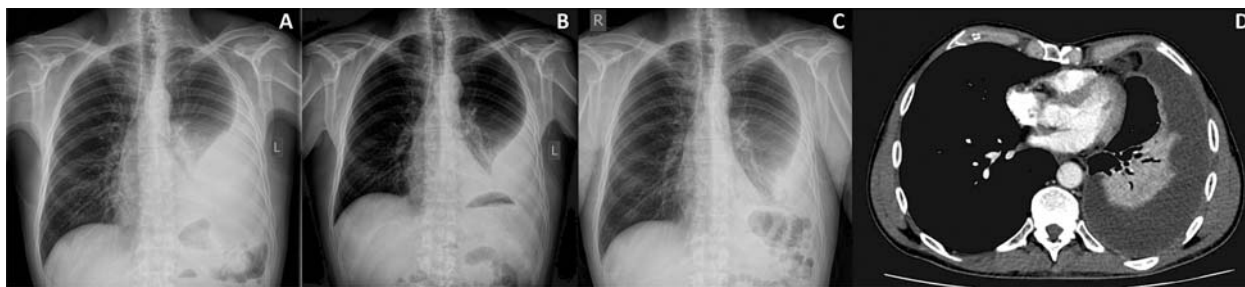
A. B. C. Series of chest X rays showing left pleural effusion decreasing under the treatment. D. Arterial phase of chest CT showing large pleural effusion on the left side with partial consolidation of the left lower lobe due to inflammatory changes with negative bronchogram sign
